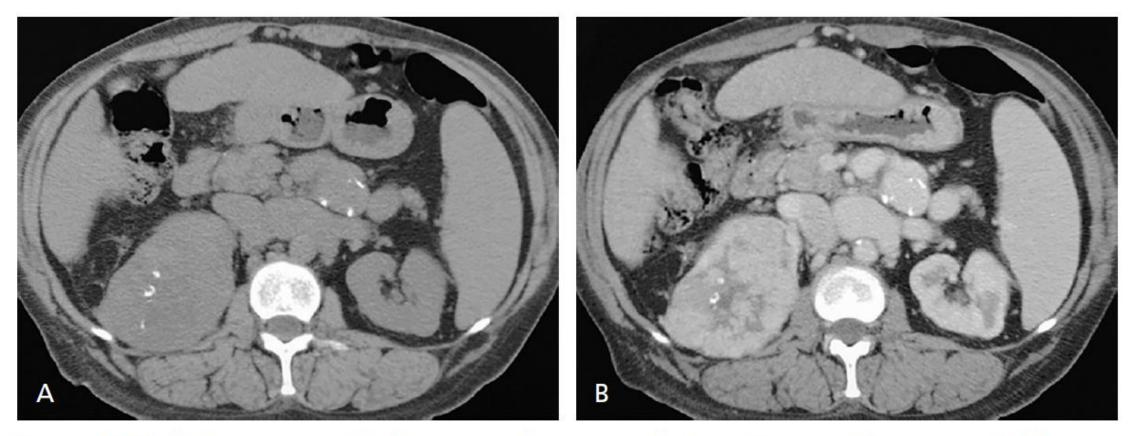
Multiphasic computed tomography urography in a 52-year-old woman with hematuria shows renal cell carcinoma. (A) Unenhanced image demonstrates right renal mass with calcification. (B) Contrast-enhanced images demonstrate a hypervascular enhancing mass.
